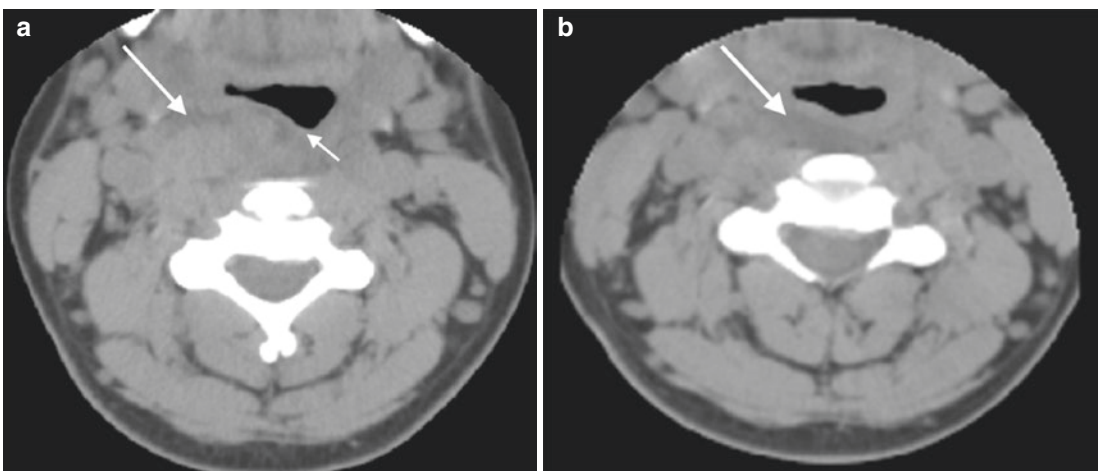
48F for fluoroscopy guided disk aspiration at C4–5 (a). The patient’s blood pressure increased significantly during the procedure (240/120 mmHg) and she complained of difficulty swallowing. Axial CT image (a) shows acute soft swelling with hematoma formation
